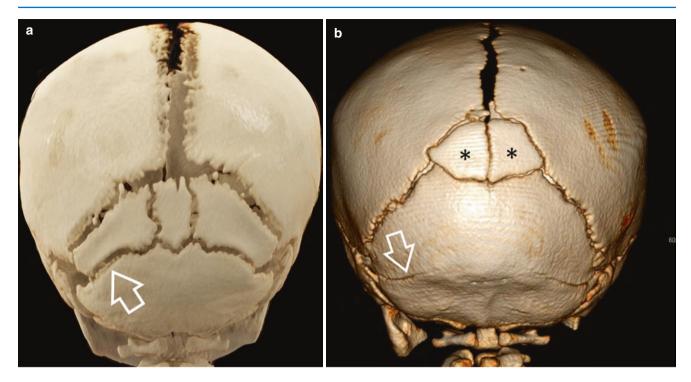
(a) 3D-CT of the occipital bone in a 6-month-old infant showing the major ossification centres of the occipital bone: single basoccipital (blue), two exoccipital (red), single supraoccipital (green), and two ossification centres of the interparietal bone (= os inca, yellow). (b)
